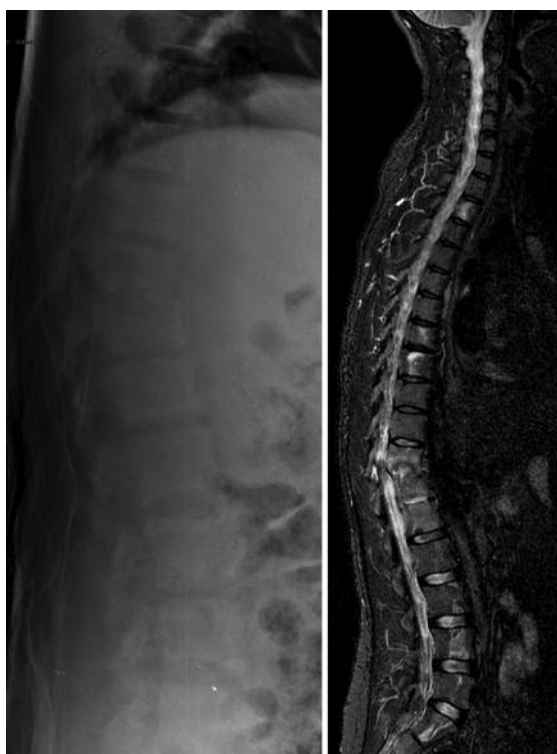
Twenty-one years old patient affected by drepanocytosis. Preoperative lateral X-ray and MRI imaging showing T7, T11, T12 and L1 vertebral fractures.
